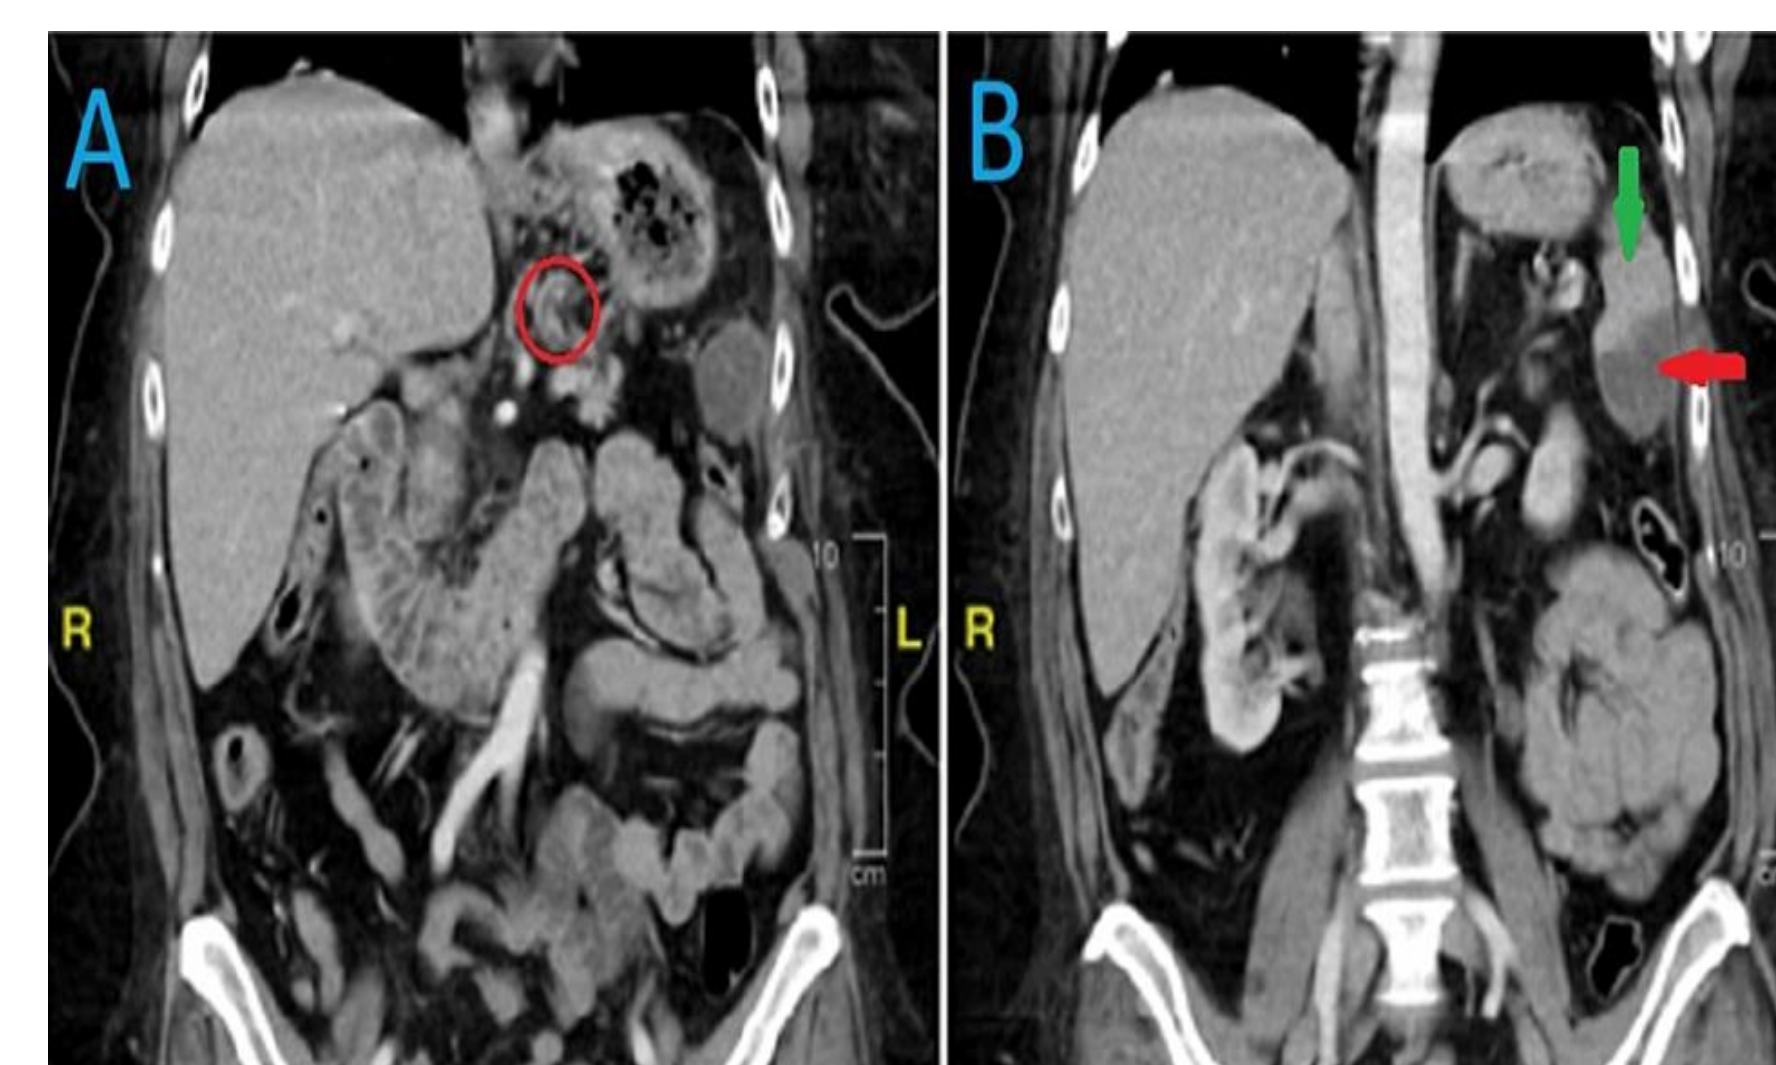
CT scan of the abdomen showing a filling defect indicating persistent thrombus in the splenic artery, as well as visible infarction in the spleen. (A) Area within the red circle indicates the location of the thrombus. (B) Green arrow indicates normal area of the spleen, which is hyperdense. Red arrow indicates the infarcted area of the spleen, which is hypodense.
